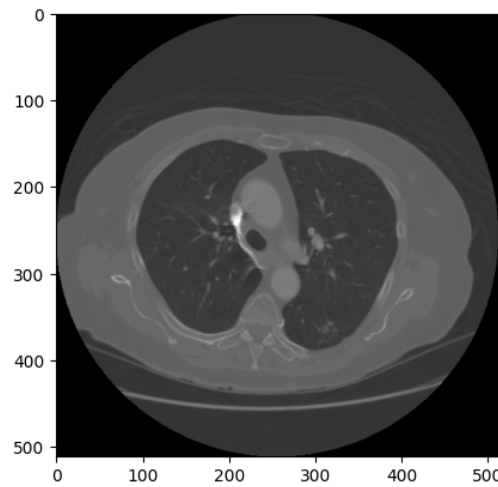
Original CT scan
